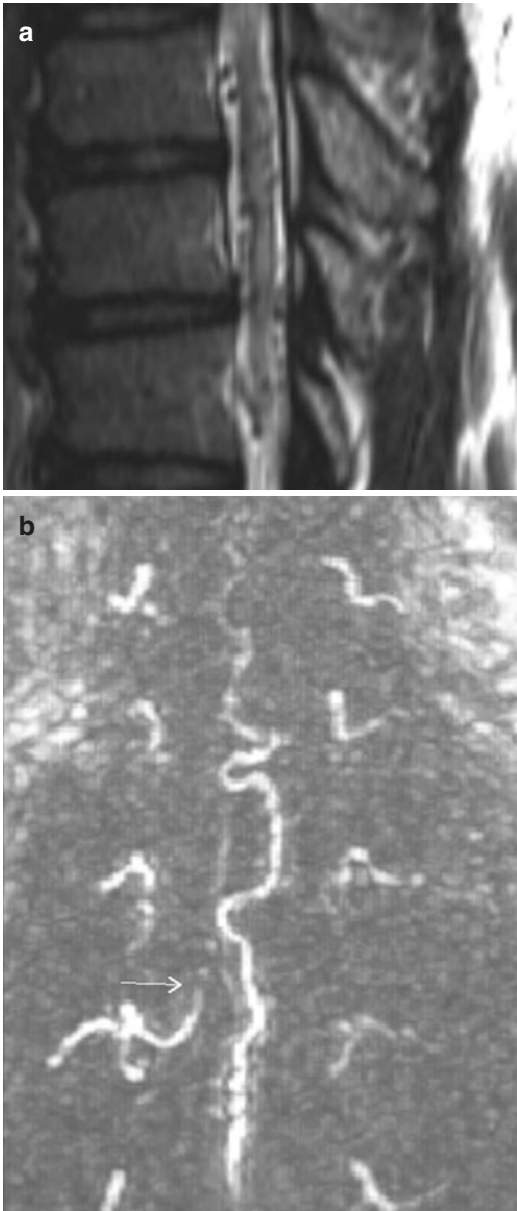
Multiple flow voids are seen on T2-weighted imaging about the cord, a common finding for vascular lesions/anomalies (a). Magnetic resonance angiography confirms a dural arteriovenous fistula and identifies a possible feeding vessel (b)
